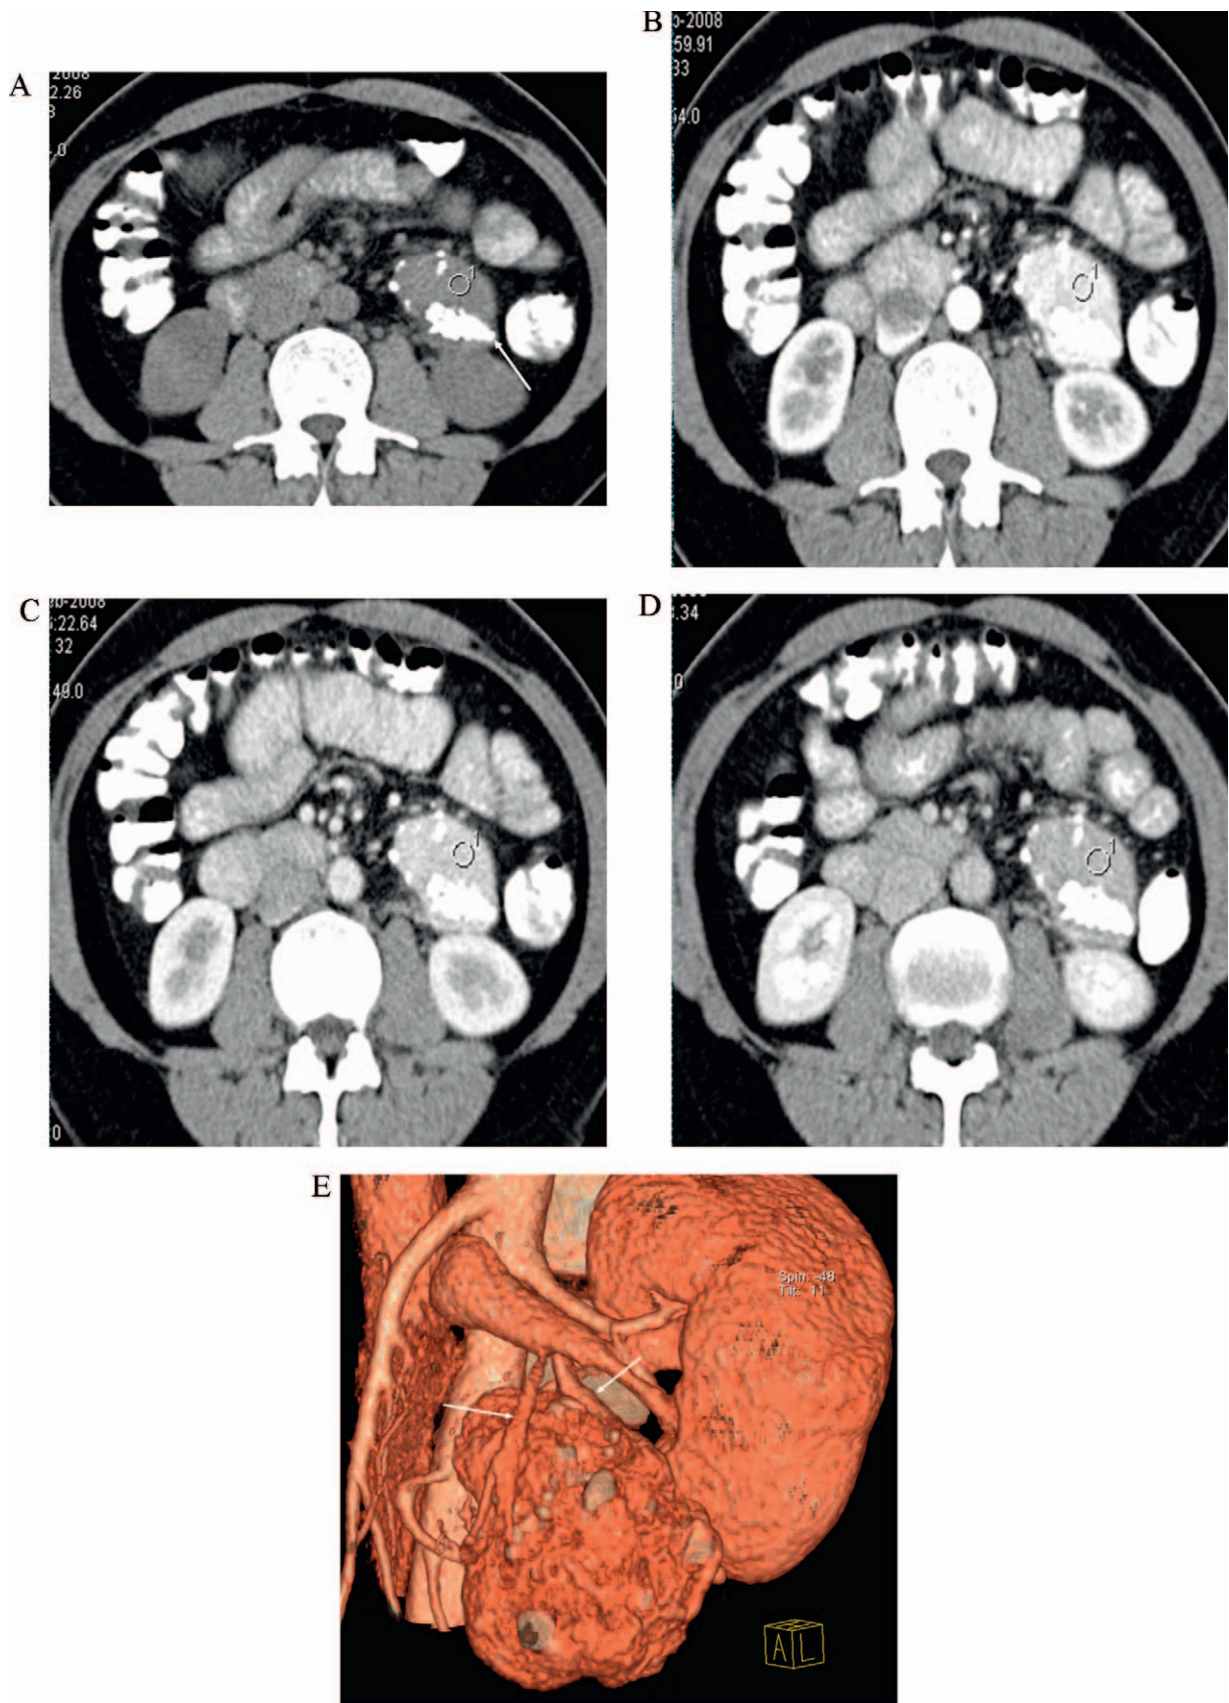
(A) 49-year-old woman with left retroperitoneal hyaline-vascular Castleman's disease who presented with vague left abdominal pain. Unenhanced abdominal axial MDCT scan shows well-defined retroperitoneal mass with typical arborizing calcifications (arrow). (B) Contrast-enhanced abdominal axial MDCT scan shows intense enhancement of mass at arterial phase (CT = 156.7Hu). (C) Contrast-enhanced abdominal axial MDCT scan shows intense enhancement of mass at portal vein phase (CT = 135.6Hu). (D) Contrast-enhanced abdominal axial MDCT scan shows moderate enhancement of mass at delayed phase (CT = 97.4Hu). (E) Volume rendering MDCT images shows the dilated feeding artery and draining vein (arrows).
